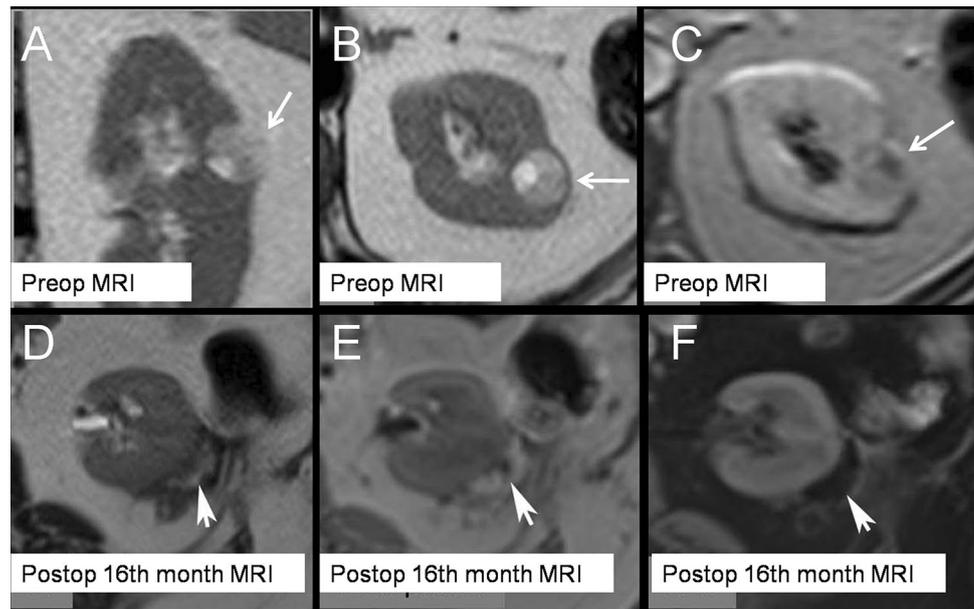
A 62-year-old woman with solid renal mass, whose pathology results indicated clear cell-type RCC. Pre-operative MRI shows a small cortical renal mass (arrows) (a, b). Tumor shows moderate enhancement (arrow) (c). Autologous fat was packed in the defect site during partial nephrectomy. In the 16th month follow-up MRI, in axial T2-weighted (d), T1-weighted (e) and fat-saturated T1-weighted images (f), crescent-shaped fat signal is seen at the operation site (arrow heads). A T2 hypointense fibrous capsule is seen around that fat package
